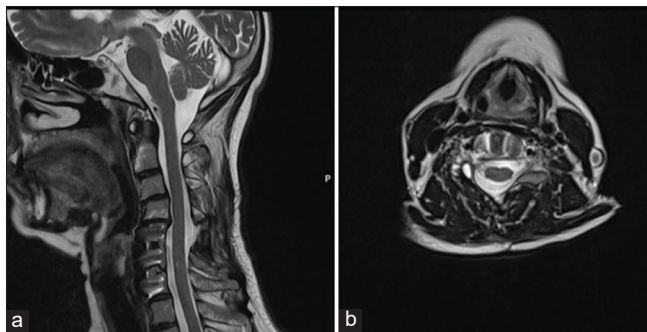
Postoperative sagittal (a) and axial (b) MRI T2-weighted scans six months after surgery revealed a complete tumor removal, no tumor remnants and recurrences.
